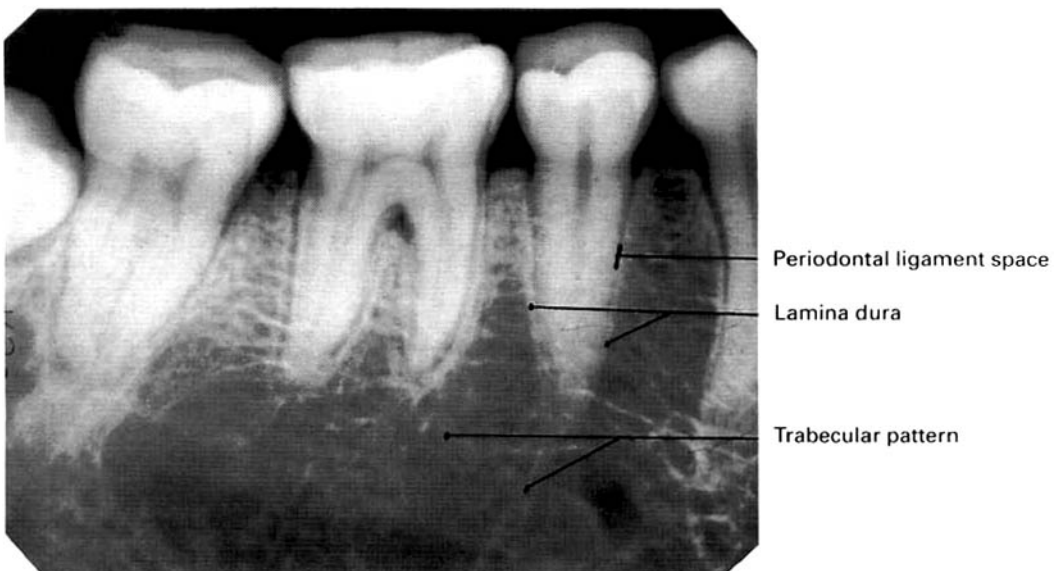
Two-dimensional radiographic image of the three-dimensional mandibular anatomy.
